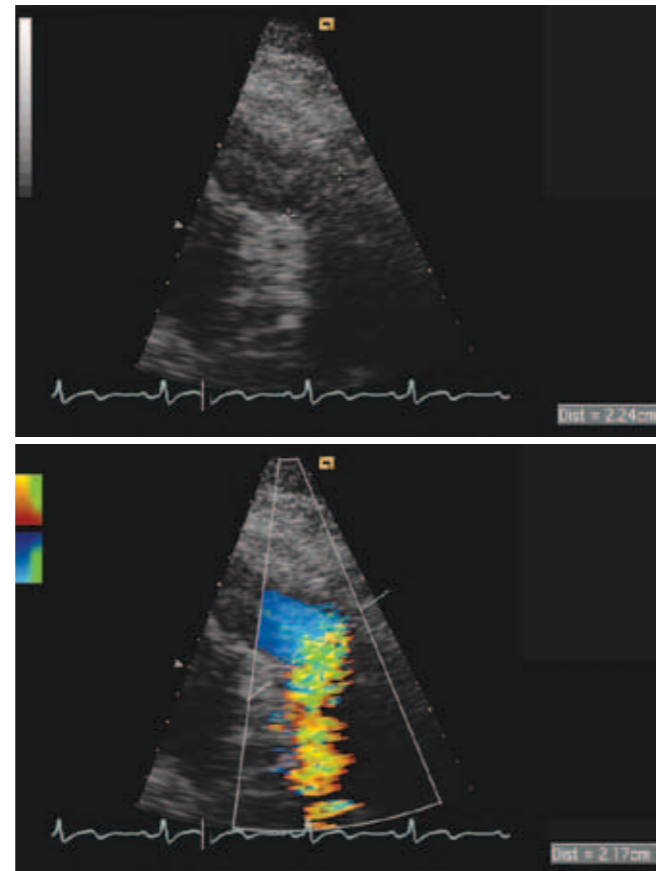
This zoomed view of the right ventricular outflow tract was recorded from the parasternal short axis view. The pulmonary annulus is measured during systole using the inner edge to inner edge technique (top). Using colour Doppler imaging, the borders of the pulmonary annulus may be enhanced to facilitate the measurement of the annulus (bottom).
